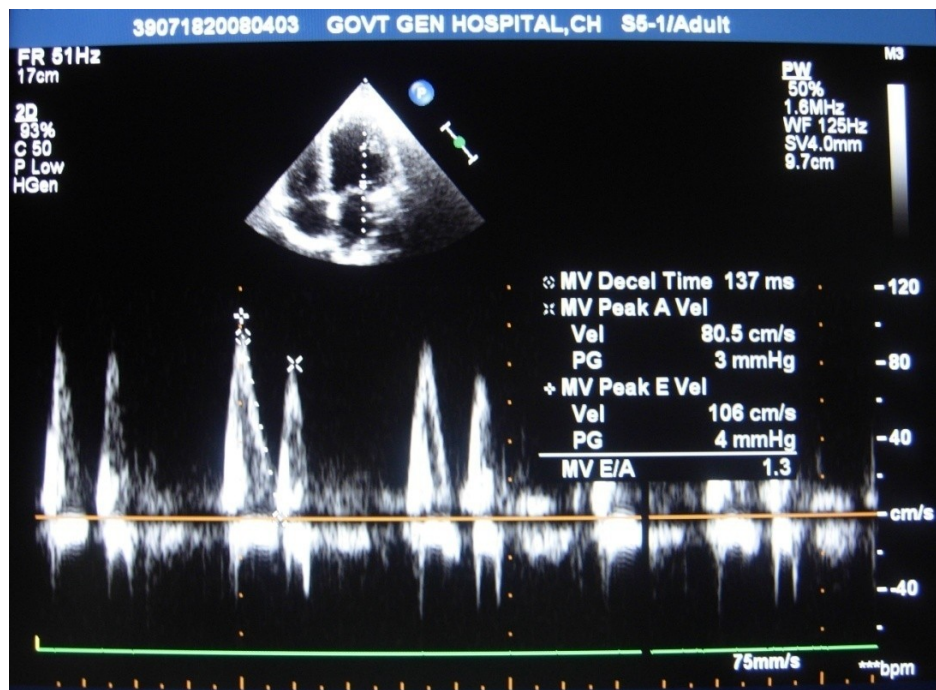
Pulsed wave Doppler echo of mitral inflow showing shortened DT (<140ms) in a patient with AWTI
